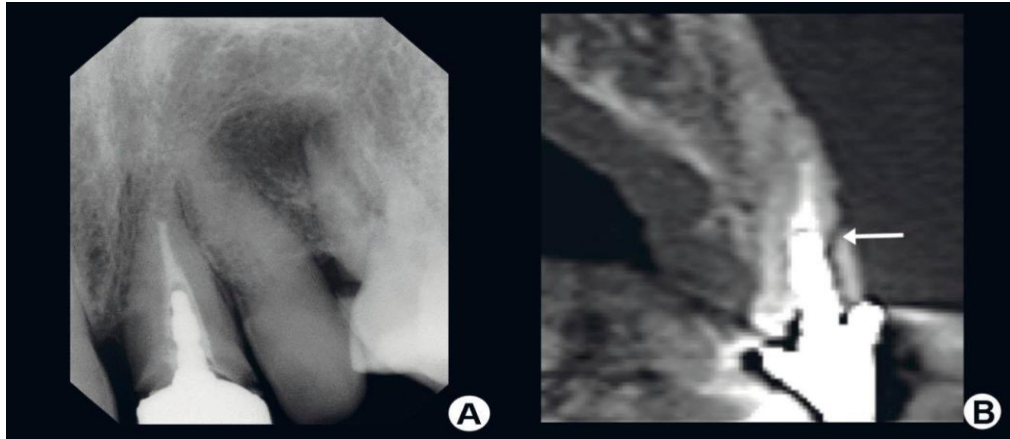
(a) Periapical radiograph of a maxillary left central incisor tooth restored with an ill-fitting crown retained by a cast post and core. There is no evidence of a root fracture on the radiograph. (b) Sagittal CBCT slice through the same tooth. A horizontal root fracture (arrow) is clearly evident. (Images courtesy of Steve Jones; Pentangle Specialist Dental Practice, Newbury, Berkshire, UK).
